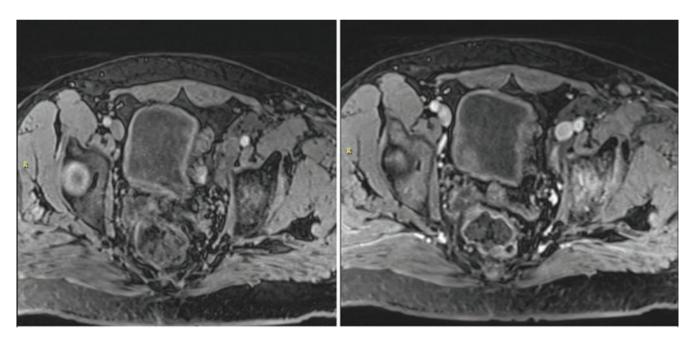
Pelvic MRI with IV contrast showed soft tissue enhancement in the left thigh and confirmed the extensive soft tissue hemangioma in this region
